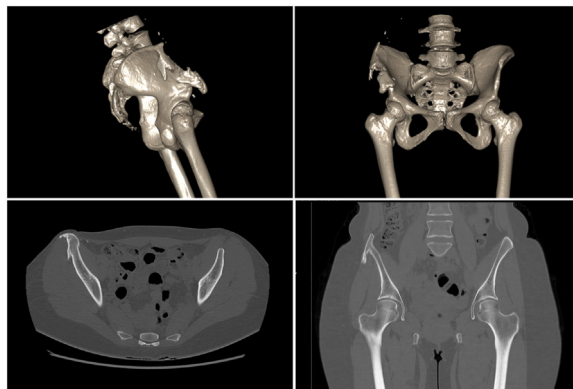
Pelvic computed tomography scan showing heterotopic ossification (32 × 57 mm) of the right iliacus bone.
